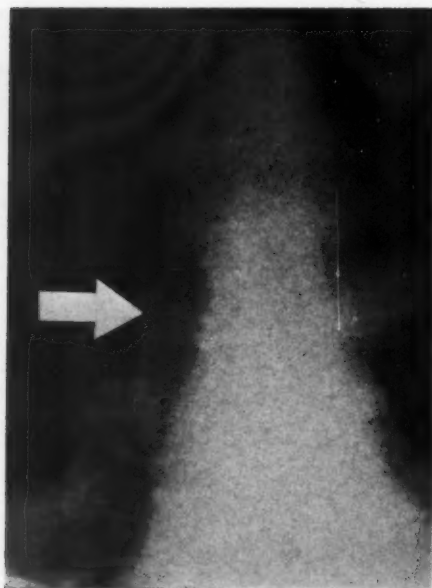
Large calcified atheroma in Part II-L, demonstrated in chest roentgenogram. Atheromatous plaques occur more frequently in Part II-M, but are hidden by the spine.
